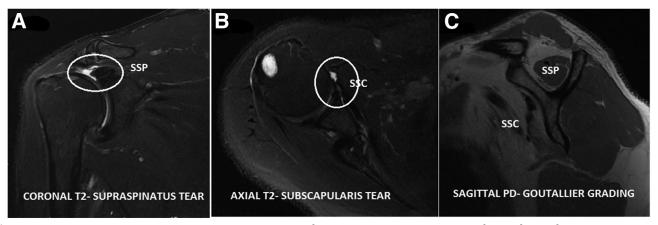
Magnetic resonance imaging preoperative. (A) Coronal T2, supraspinatus tear. (B) Axial T2, subscapularis tear. (C) Sagittal Proton Density (PD) image, Goutallier grade, supraspinatus gr 2, subscapularis gr 4.
